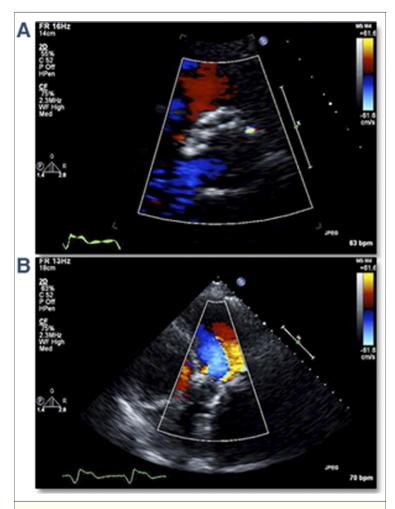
Severity of Aortic Regurgitation Varies in Different Echocardiographic Windows
